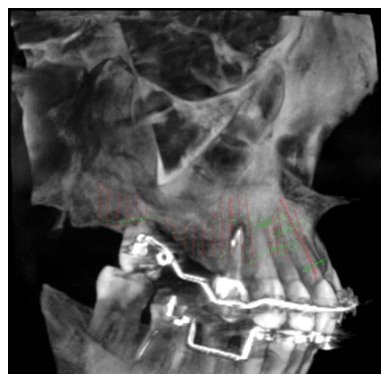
Right upper wisdom tooth (tooth 18) mesially tipped. Uprighting attempt. CBCT – 3D reconstruction. CBCT: Cone-beam computed tomography.
